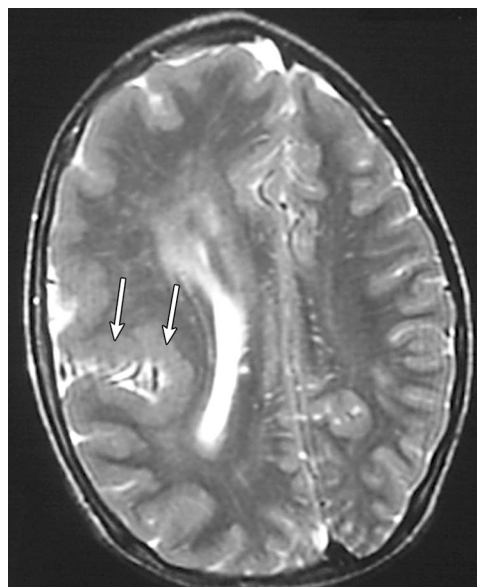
Asymmetric megalencephaly. Axial T2-weighted MR image of the head of a patient aged 7 years shows broad gyration and diffuse enlargement of the right cerebral hemisphere, closed-lip schizencephaly beginning at the right lateral sulcus (arrows), and prominence of the Virchow-Robin spaces.
